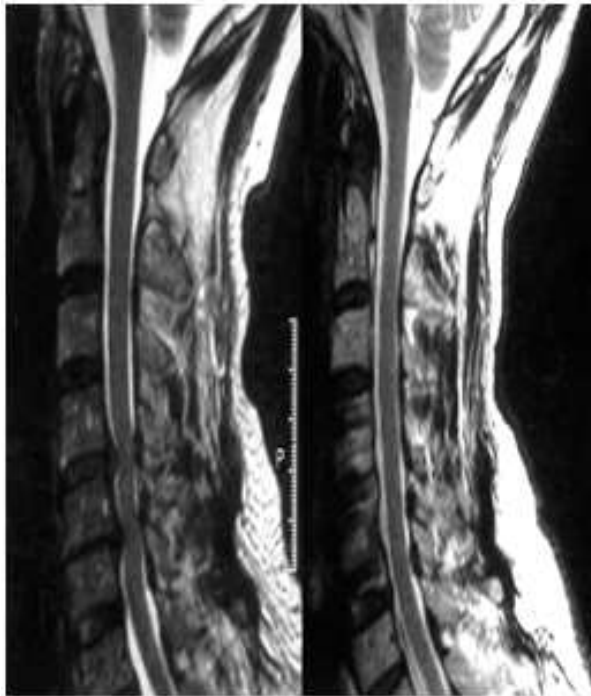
MRI cervical spine showing Spondylosis
